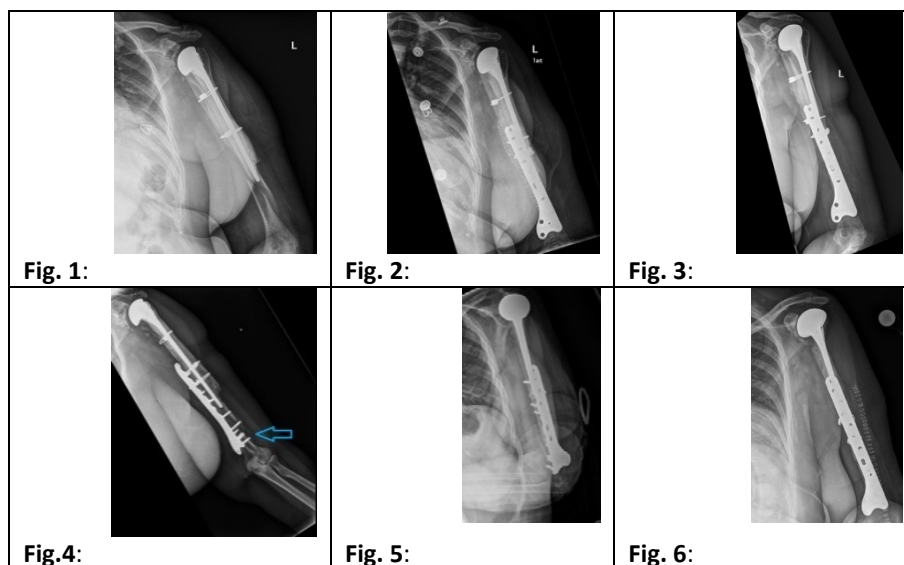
Figure 1 shows a pre-operative AP Radiograph of Patient #1.
